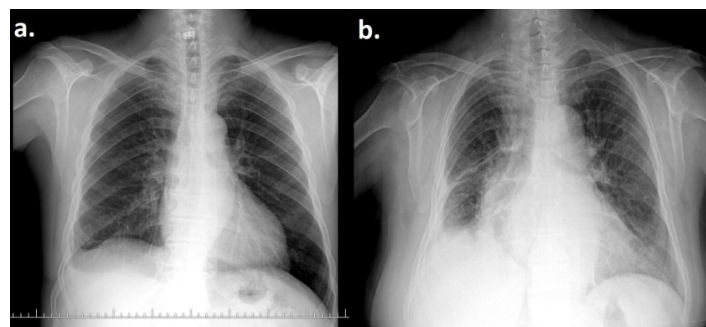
(a) The first-month follow-up chest X-ray reveals right sinus bluntness with mild costal pleural thickening of the right hemithorax, (b) Another patient's first-month follow-up chest X-ray observed excessive thickening of the right costal pleura, narrowing of the intercostal spaces, and effacement of the diaphragmatic borders. In this patient, video thoracoscopic surgery was considered unsuccessful, and total pleural decortication with thoracotomy was performed
